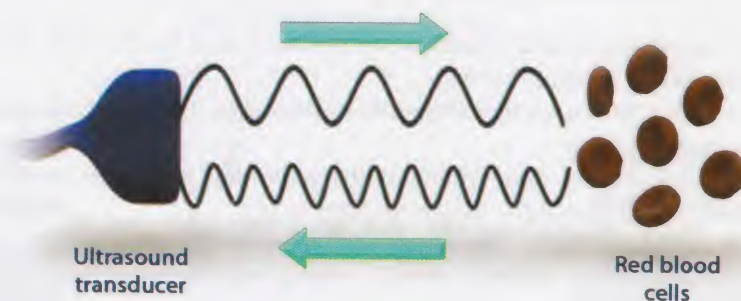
Doppler frequency shift
